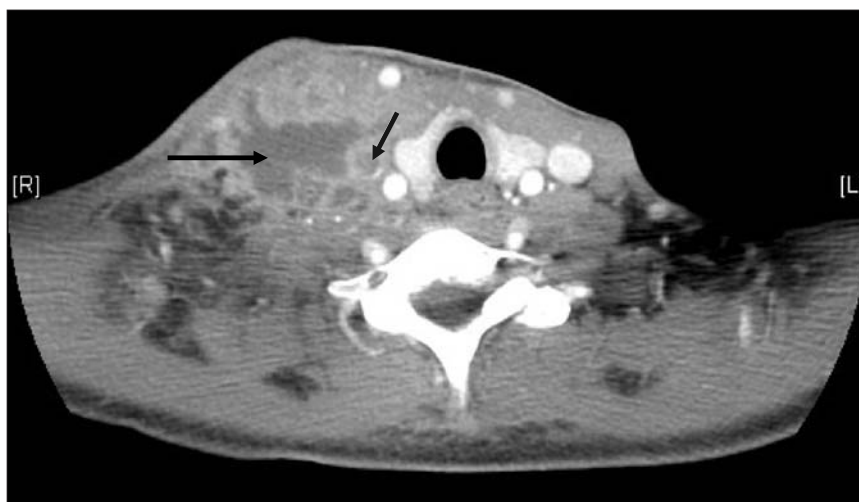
CT scan of the neck with contrast. The left arrow indicates the multiloculated abscess. The right arrow indicates the right internal jugular vein with a tiny ring of contrast around the occluding thrombus.
